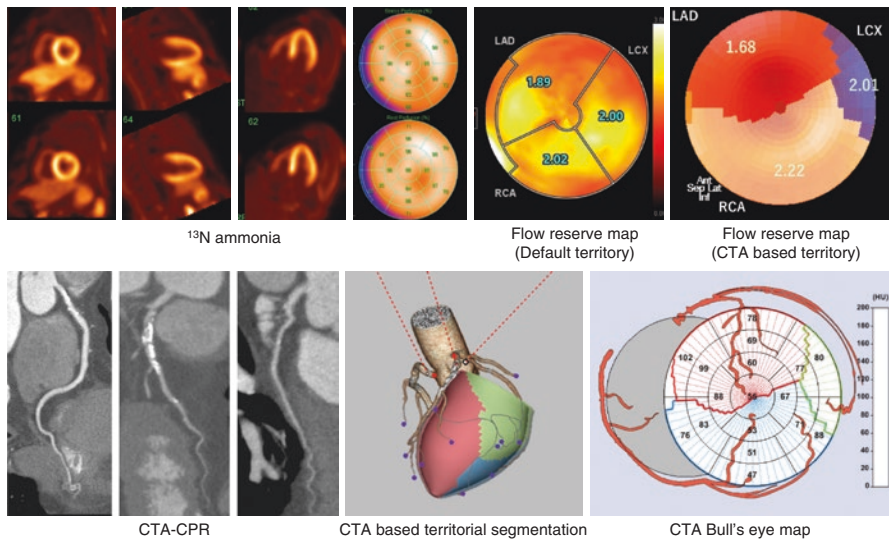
Territorial analysis derived from 3D image fusion of CTA and PET is shown. CPR images show significant atherosclerosis in proximal LAD and suspect of obstructive. PET flow reserve map shows impaired flow response in anterior wall, while relative perfusion is normal from rest/stress static images. In default territorial map shows relatively impaired flow reserve in LAD territory (1.89). However, it shows 1.68 from patient based territorial flow analysis
